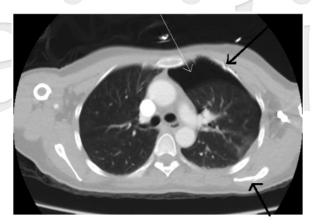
Chest computed tomography shows left pneumothorax (white arrows) affecting the left second, third, and fourth ribs and left scapular bone fracture (black arrows).
